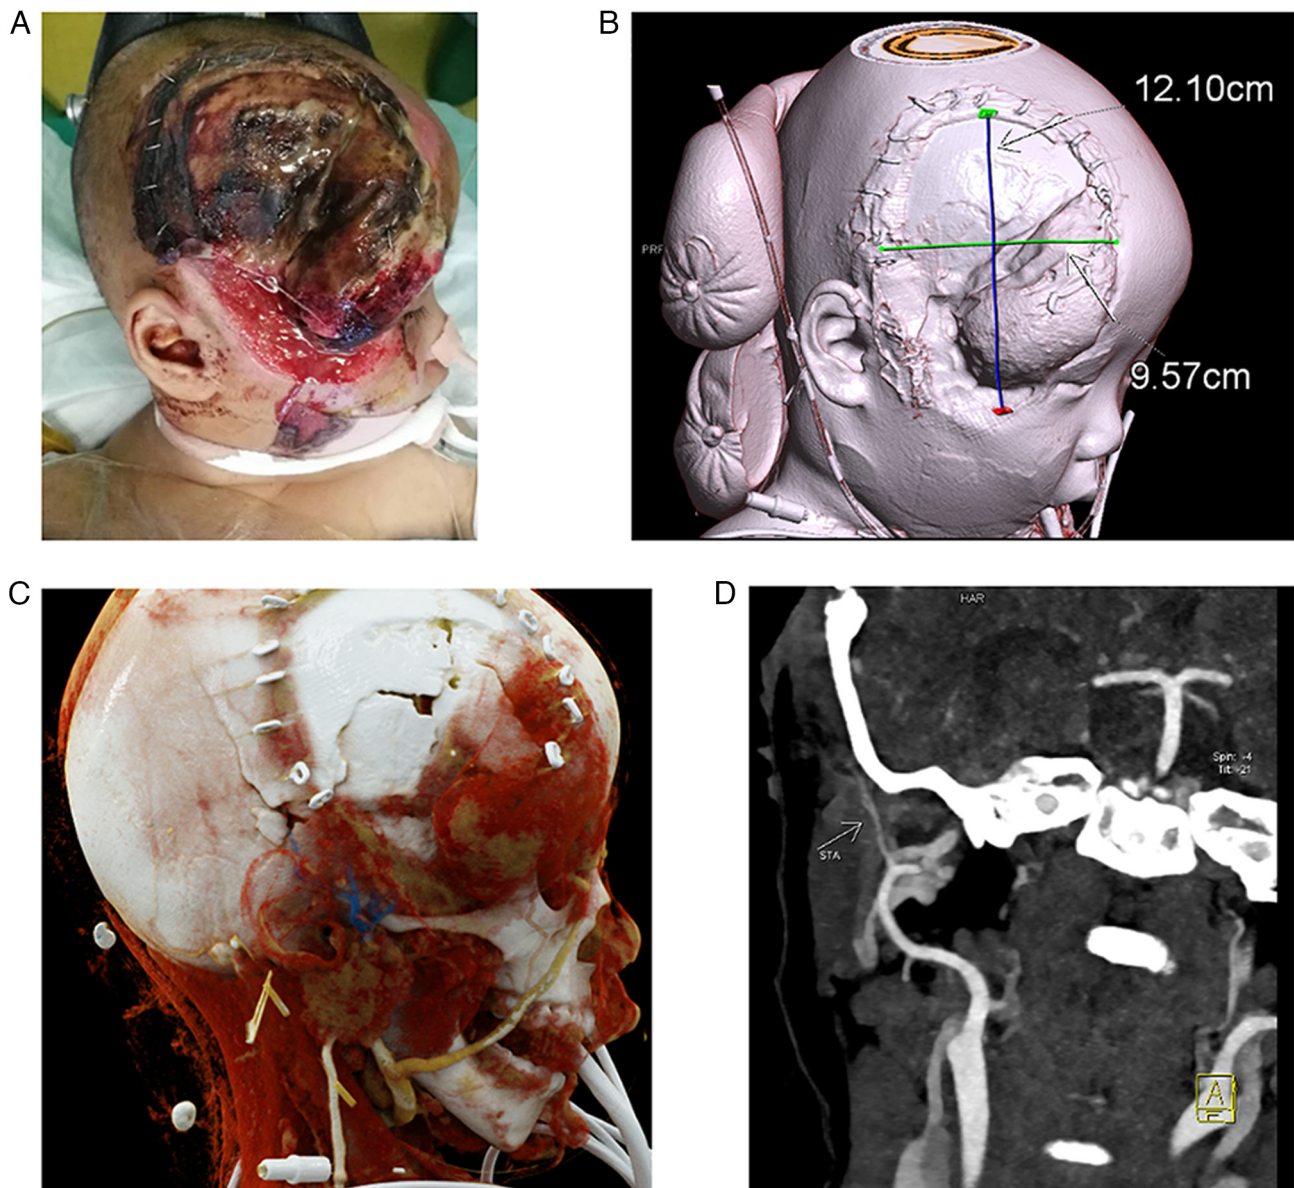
Preoperative situation. (A) Allograft skin covering the brain tissue. (B) 3D-CTA showing the extent of the scalp defect. (C) 3D-CTA showing the vessels in the auriculotemporal region, with arteries in red and veins in blue. (D) White arrow in the CTA pointing to the severed end of the superficial temporal artery. 3D-CTA, three-dimensional computed tomography angiography; STA, superficial temporal artery.
